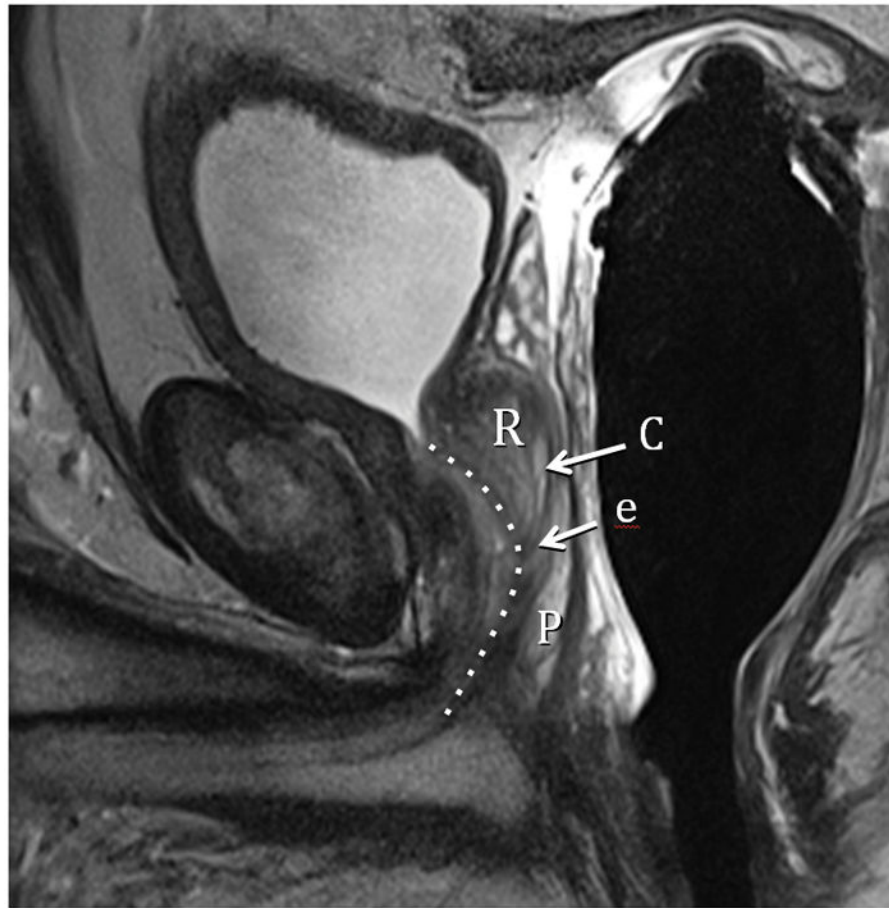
Type 0 (Normal) T2-weighted sagittal view at 3T with ERC (C=central Zone, P=peripheral Zone, ed=ejaculatory Duct, afm=anterior fibromuscular zone, dotted line=urethra). Fig. 1B. Type 0 (Normal) T2-weighted image at 3T with ERC at level above the veru. TZ=transition zone, P=peripheral zone. Note minimal TZ hyperplasia, very little, if any compression of the PZ, and overall volume of prostate < 25 cc. Fig. 1C. Type 0 (Normal) T2-weighted Axial View at 3T with ERC at level of verumontanum (V). P=peripheral zone.
